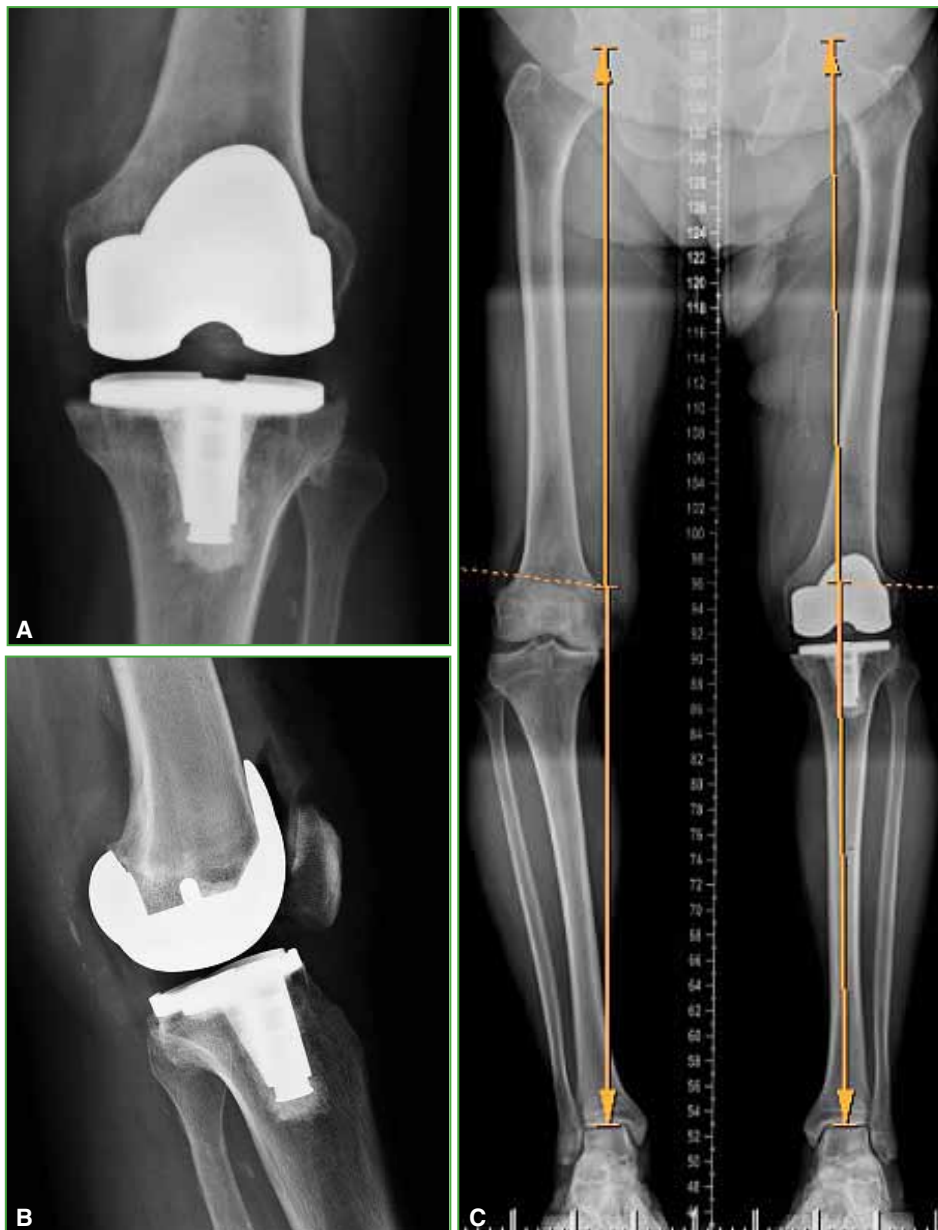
A and B. Anteroposterior and lateral knee radiographs. C. Postoperative scanogram.
